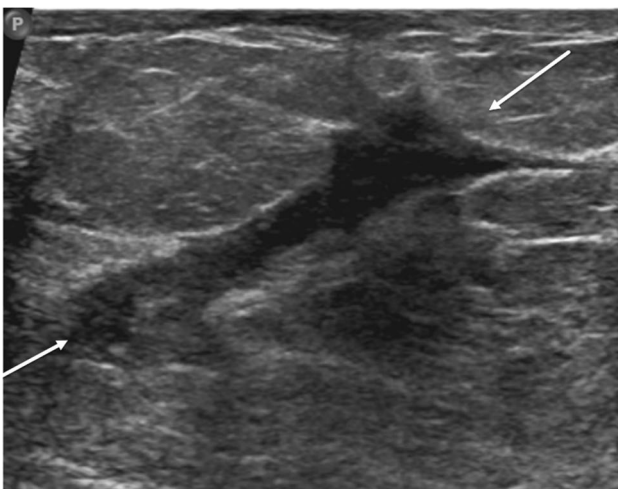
31-year-old with a galactocele, initially detected on palpation during the third trimester of pregnancy and diagnosed at 6 weeks postpartum. Upon placement of the needle, milky fluid was returned. Transverse ultrasound shows a complicated cystic mass (arrows) with posterior acoustic enhancement (circle)
